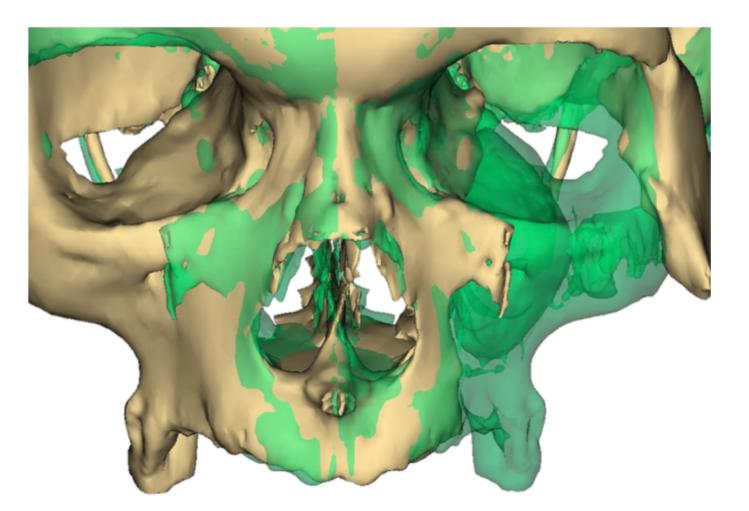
CT-3D Reconstruction - Preoperative Defect
